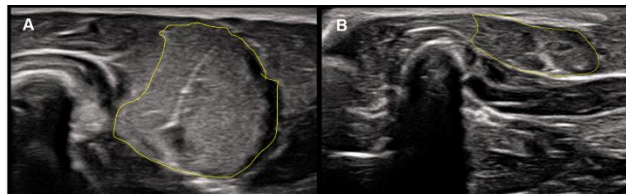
Ultrasound image of the extensor carpi radialis muscle (yellow line outlines the cross-sectional muscle area) before and after 12 months of denervation in NHP2.
